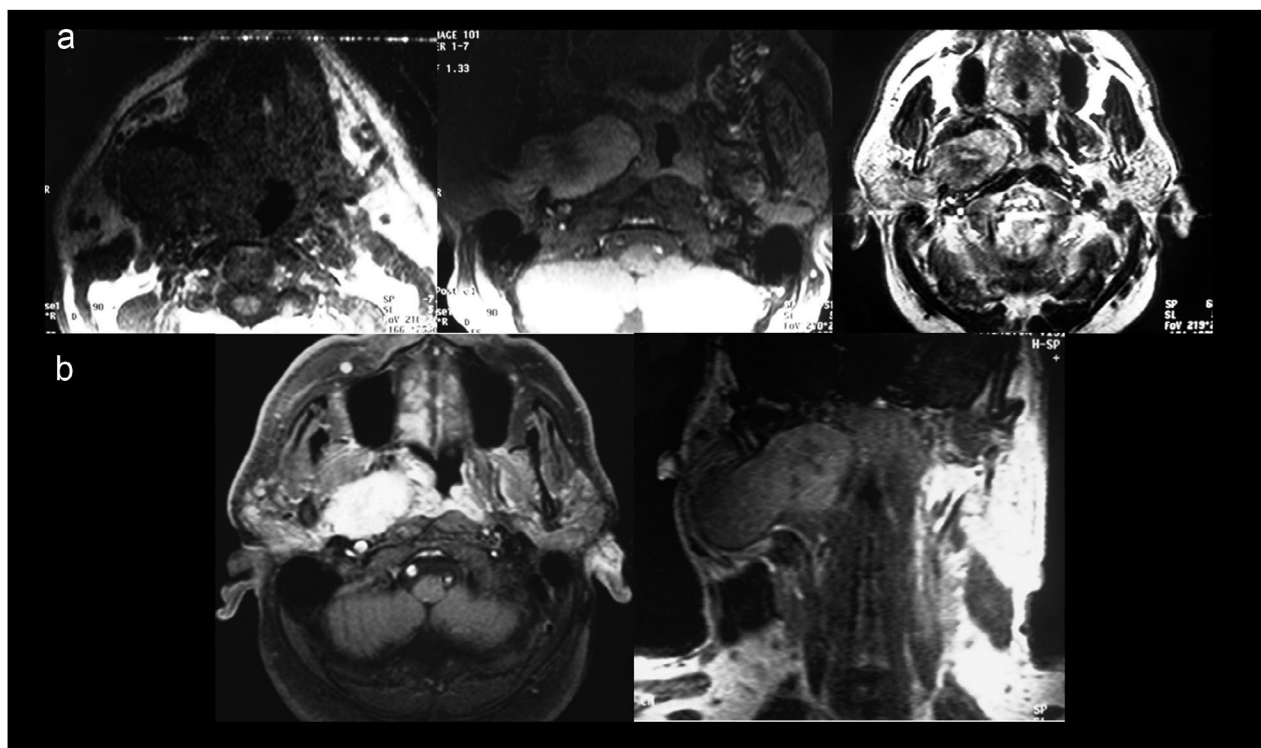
Hemangiopericytoma, (a) axial fast spin-echo T1 and T2-weighted magnetic resonance (MR) images showed large mass to have homogeneously increased signal with prominent signal voids, which corresponded to enlarged vessels, (b) gadolinium-enhanced fast spin-echo T1-weighted MR images show homogeneous enhancement of the mass with multiple signal flow voids representing large tumor vessels.
